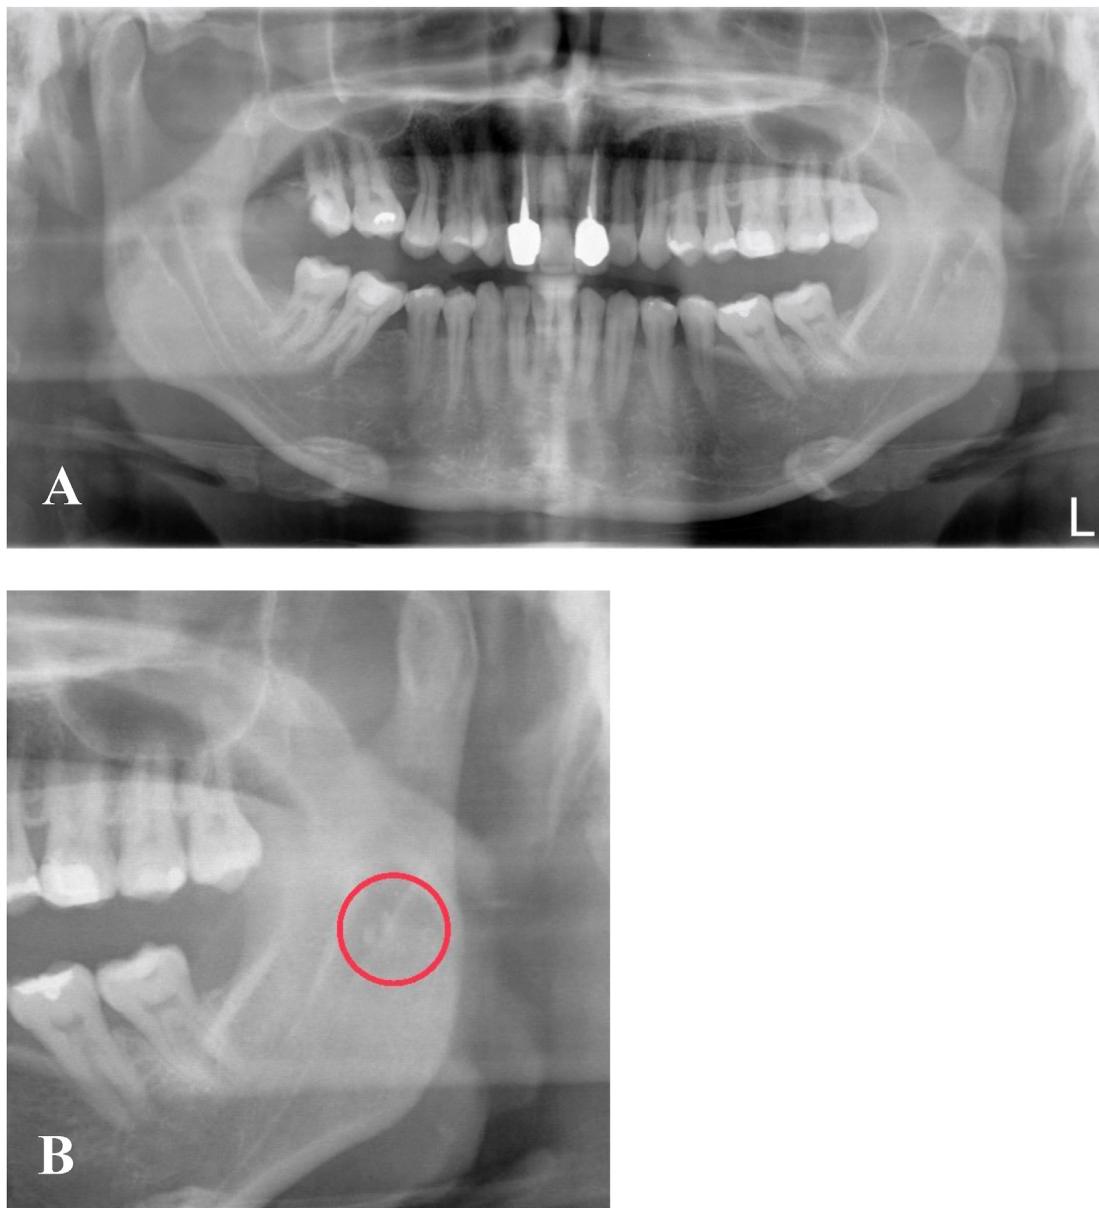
The multiple small palatine tonsilloliths detected on the panoramic radiograph of our patient. (A) On the panoramic radiograph taken at the first visit for the consultation of a soft tissue mass on the left upper buccal mucosa, there were the multiple small calcified masses superimposed on the middle level of the left mandibular ascending ramus. (B) The partial magnification of the left side of the mandibular ascending ramus revealed that these small radiopaque nodular masses were most likely the palatine tonsilloliths, because they were characteristic calcified masses located at the level of the left palatine tonsil.
